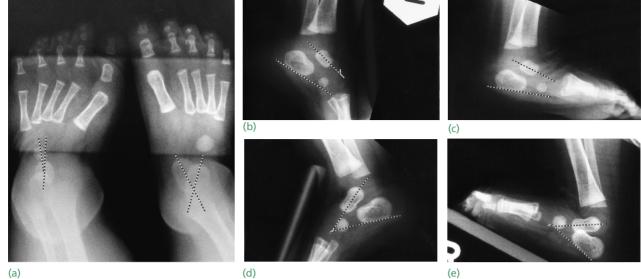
Talipes equinovarus - X-rays The left foot is abnormal. In the anteroposterior view (a) the talocalcaneal angle is 5 degrees, compared to 42 degrees on the right. In the lateral views, the left talocalcaneal angle is 10 degrees in plantarflexion (b) and 15 degrees in dorsiflexion (c). In the normal foot the angle is unchanged at 44 degrees, whatever the position of the foot (d,e).
